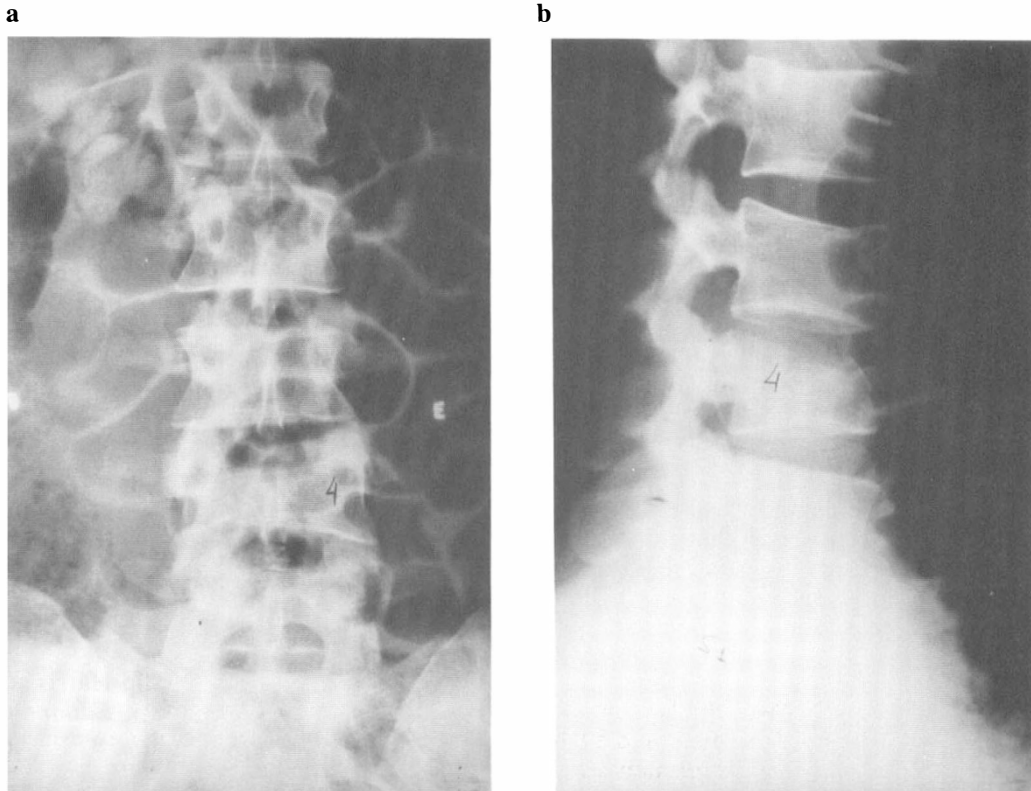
Radiographs showing L4 fracture. (a) Anteroposterior film. (b) Lateral film.
